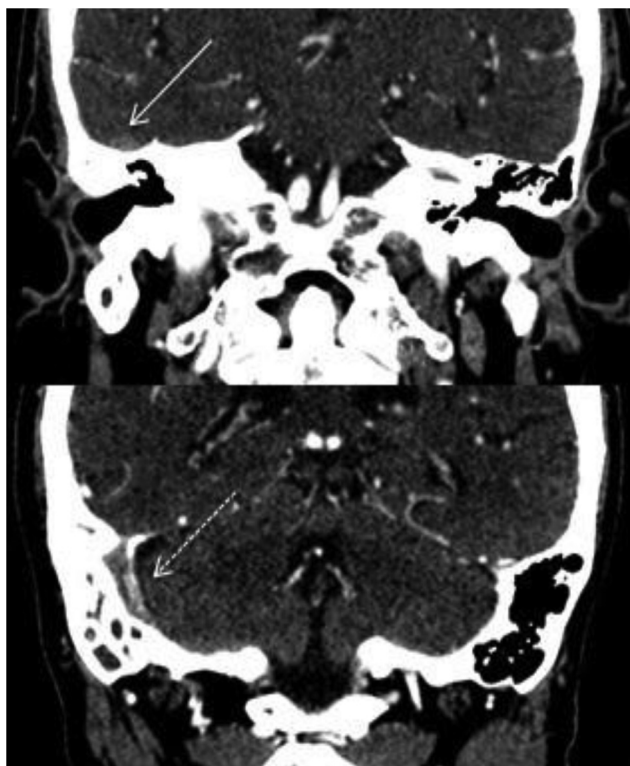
Computed tomography scan of multislice contrasted skull (March 2016) - atrophy of the right mastoid, with signs of thrombosis of the sigmoid sinus (lower arrow).
